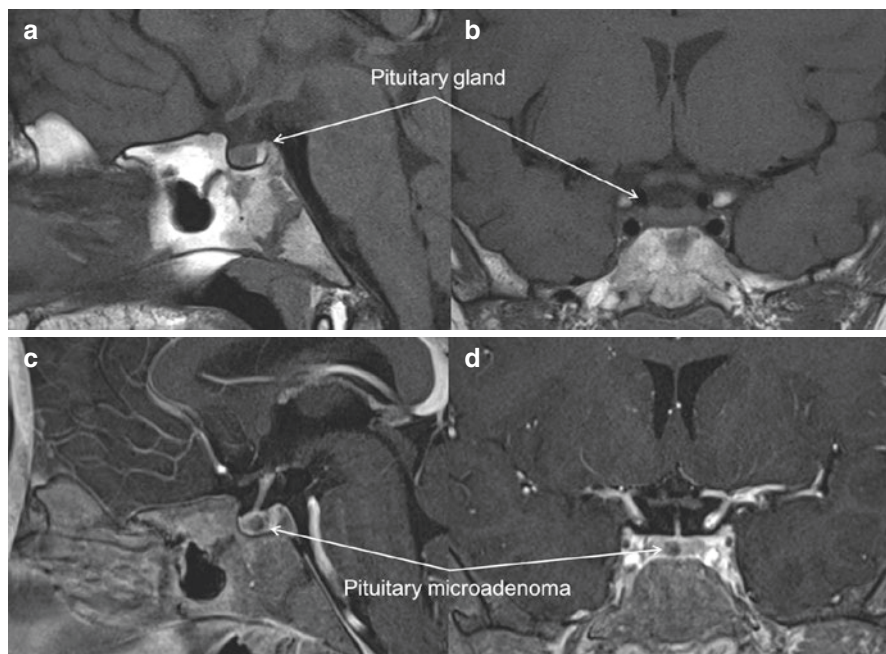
MRI imaging of a 15-year-old patient with CD. The pituitary adenoma is not seen at the pre-contrast sagittal (a) or coronal (b) T1 images but is present as hypoenhancing lesion at the post-contrast sagittal (c) and coronal (d) T1 images
